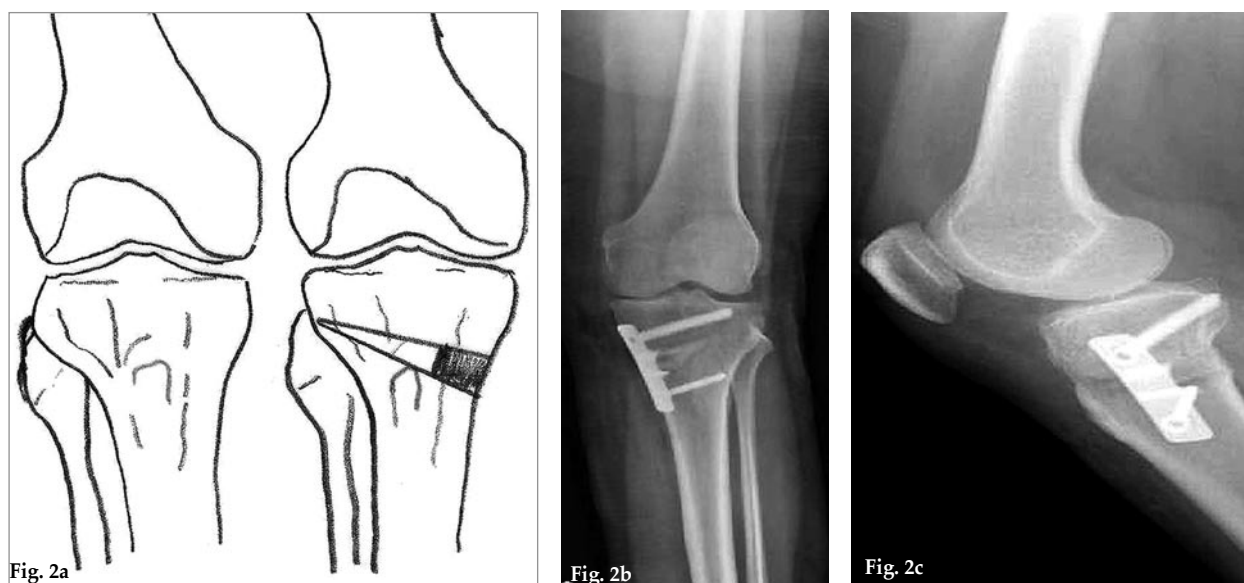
a: Medial opening wedge high tibial osteotomy. (b) Anteroposterior radiograph of 51-year-old female patient in the 2<sup>nd</sup> post-operative year. (c) Lateral radiograph of the same patient.
